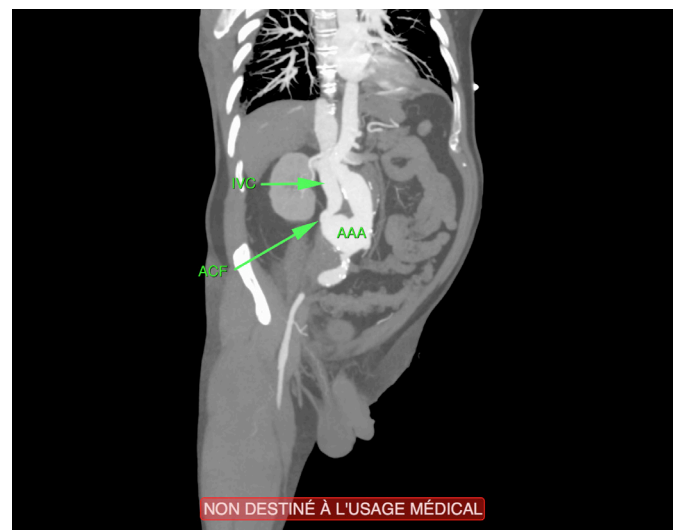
CT-scan image of aorticaval fistula (oblique coronal view) ©NCazes
